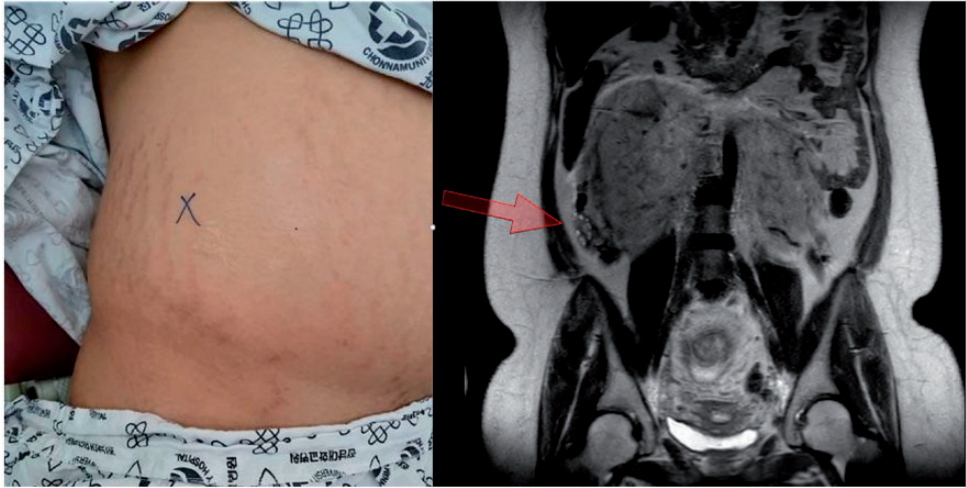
Prominent tender point and MR image. The marked point was confirmed to match the position of the right adnexa in the MR image. MRI, magnetic resonance.
